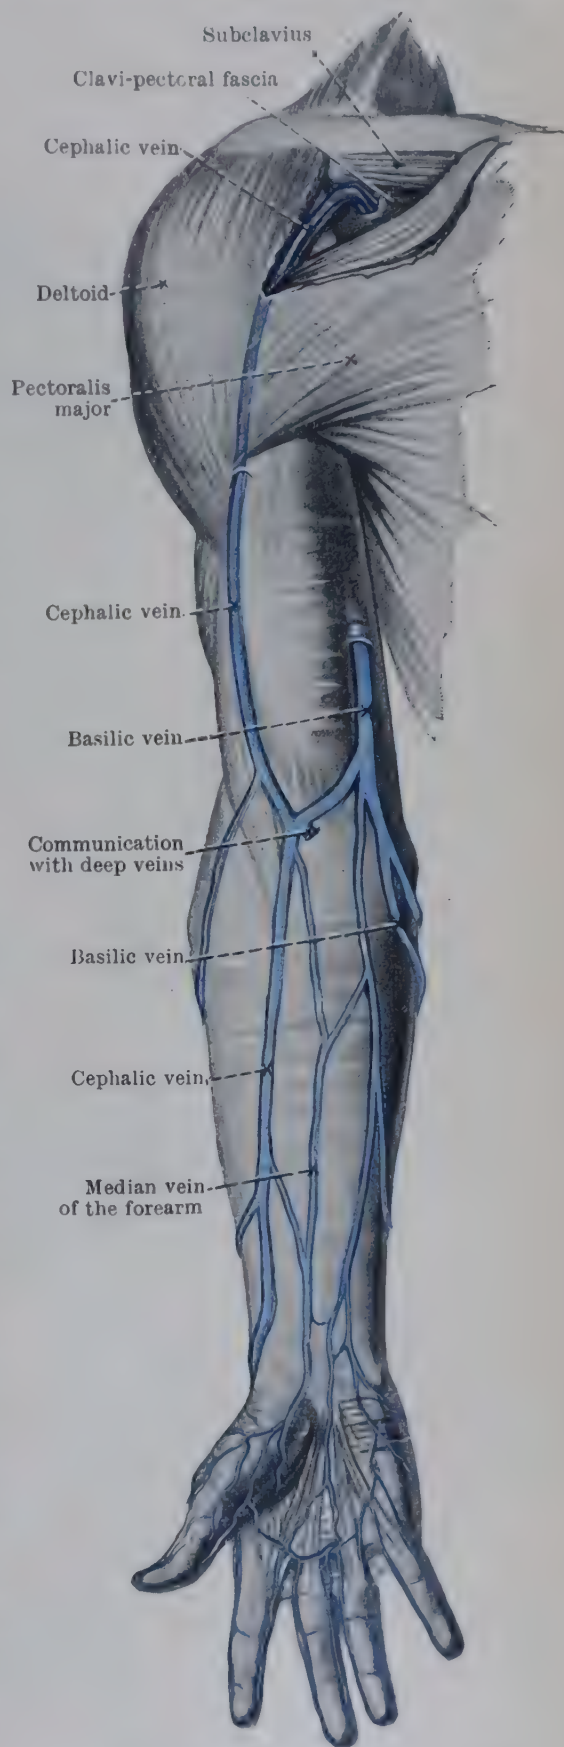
SUPERFICIAL VEINS ON FLEXOR ASPECT OF RIGHT UPPER LIMB.
